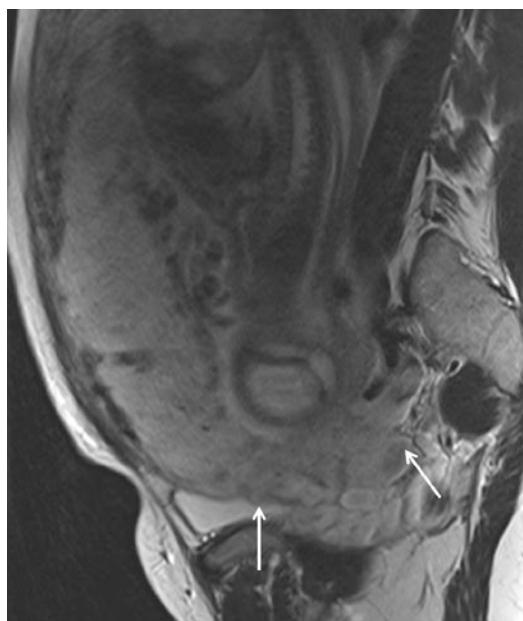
A 28-year-old woman at 30 weeks' gestation with acute pelvic pain. Sagittal T2-weighted MR HASTE image shows multiple irregular areas of the placenta bulging into the myometrium, with invasion of the right parametrium (arrows). These findings indicate placenta percreta. A hysterectomy was performed at delivery, which confirmed the MR findings
